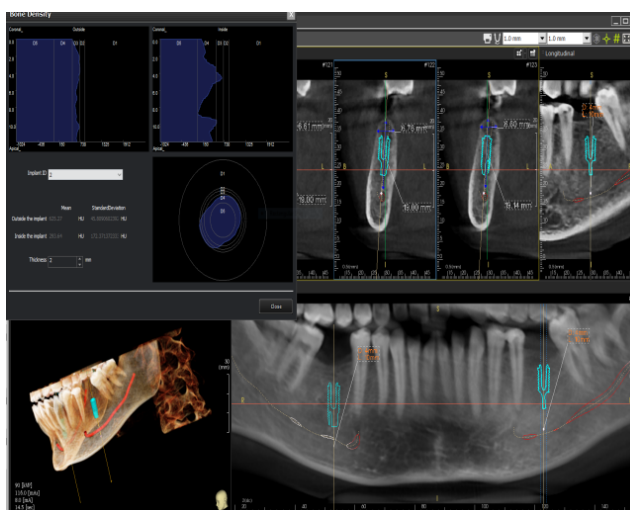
Preoperative CBCT (before implant placement)
